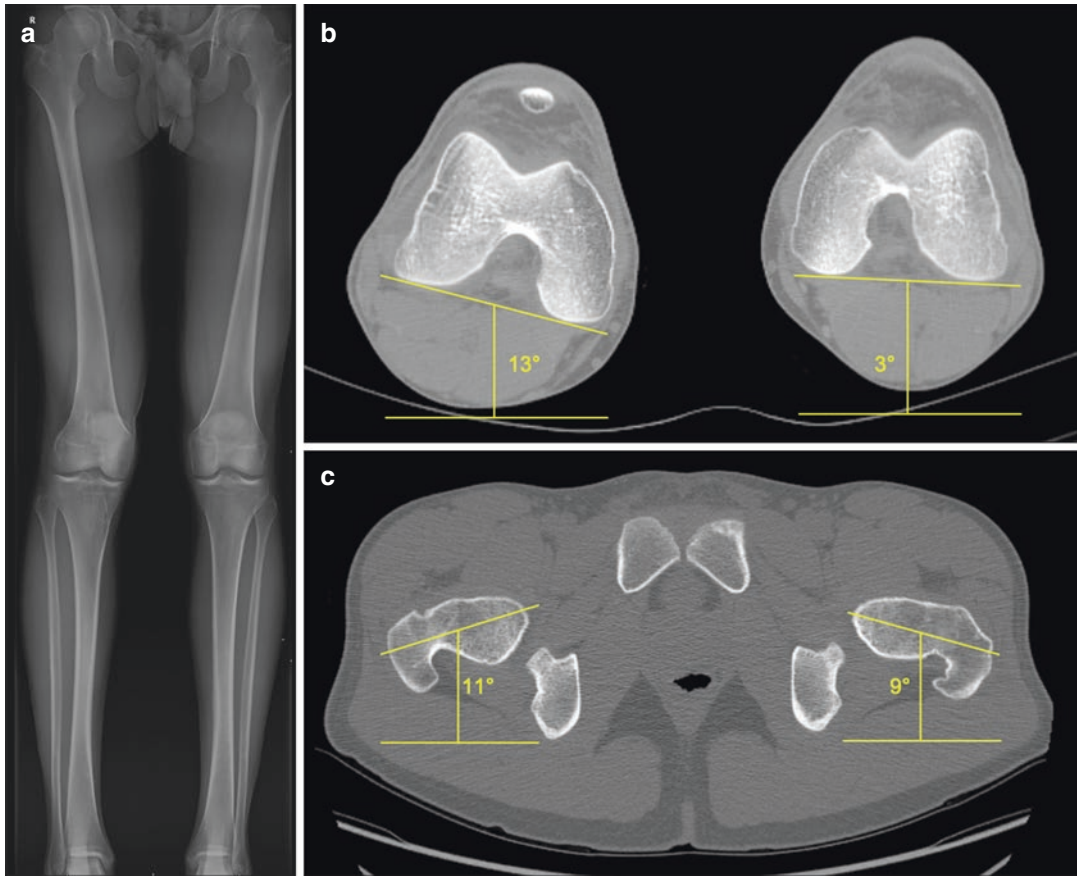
Preoperative planning for femoral derotational osteotomy. (a) Full-length standing lower extremity x-ray of a 24-year-old male, demonstrating right lower extremity valgus with increased mFTA and mL DFA after ACL reconstruction. (b) On axial CT cuts through the distal femur, angle of posterior femoral condyles to horizontal is
